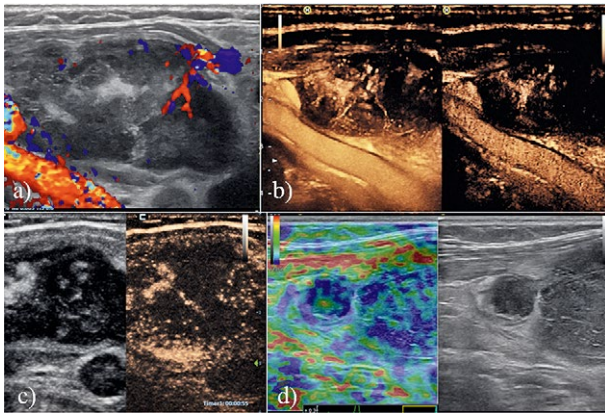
A 53 year old female with growing thyroid nodule. Anaplastic carcinoma was revealed by core needle biopsy. Color Doppler revealed only few vessels (a). Hypovascularity was proven by two contrast techniques, conventional (b) and using so-called microbubble tracing imaging (c). Elastography revealed stiff cervical lymph nodes (d).
